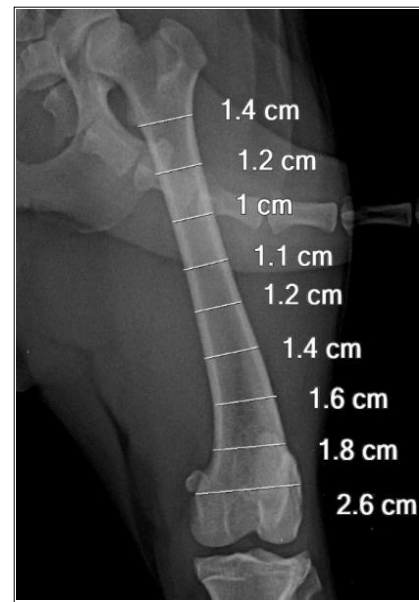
Radiograph showing trans-cortical diameter of femur at different distances in cranio-caudal view.
